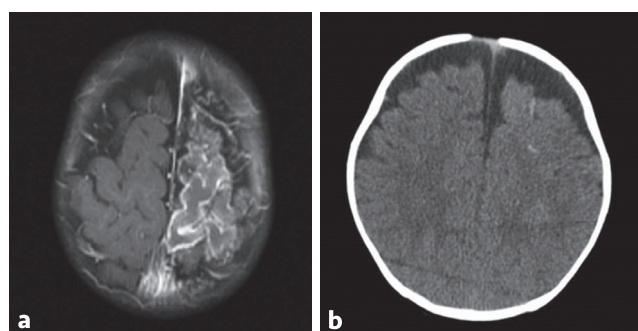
a) Cranial magnetic resonance; pathological contrasts in the cortical regions involving the left hemisphere and in the leptomeningeal structures, b) brain computed tomography; calcifications in the left hemisphere
